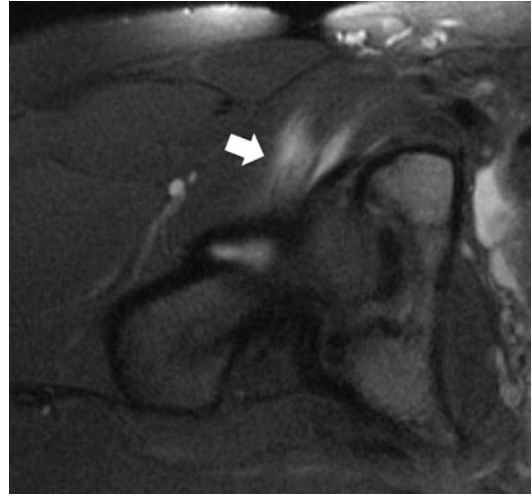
Myotendinous iliopsoas partial tear. Axial fat-suppressed T2w MR image shows a feathery oedema pattern at the myotendinous junction (arrow)
